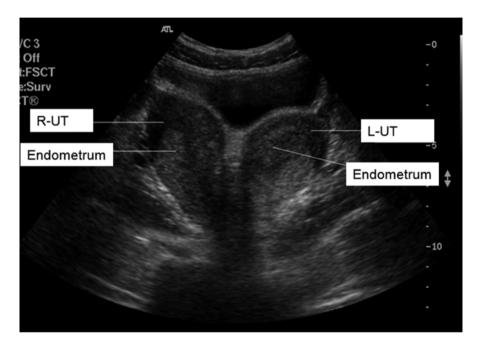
Abdominal ultrasound showing double uterine abnormalities. It shows both the left and right uteri, with uterine body completely separated and two separate endometrial echoes
